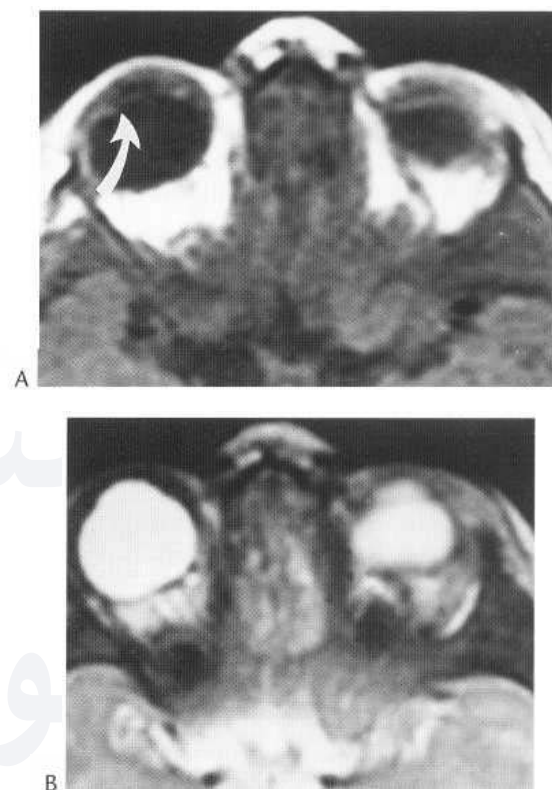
Congenital absence of the lens. Axial T₁- (A) and T₂-weighted (B) MR images demonstrate bilaterally mis-shapen globes, with microphthalmia, on left. Lens is not visualised. Presence of the ciliary mechanism (arrow) differentiates congenital absence of the lens from ocular cyst in this case.
